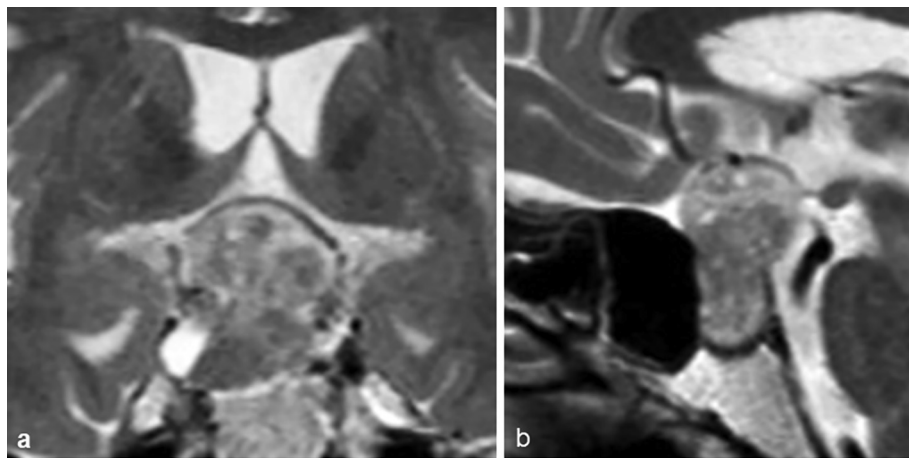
T2-weighted MR image, coronal (a) and sagittal (b), demonstrated mixed intensity mass, compressing optic nerves upwards, in the sella and supra-sella portion.
